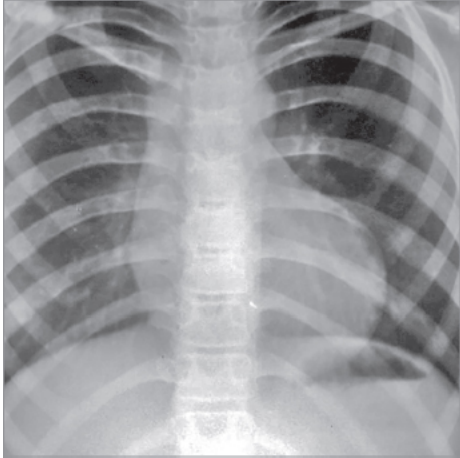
Chest X-ray PA view showing pulmonary oligemia with upturned apex (right ventricle) suggestive of tetralogy of Fallot (coeur-en-sabot).
